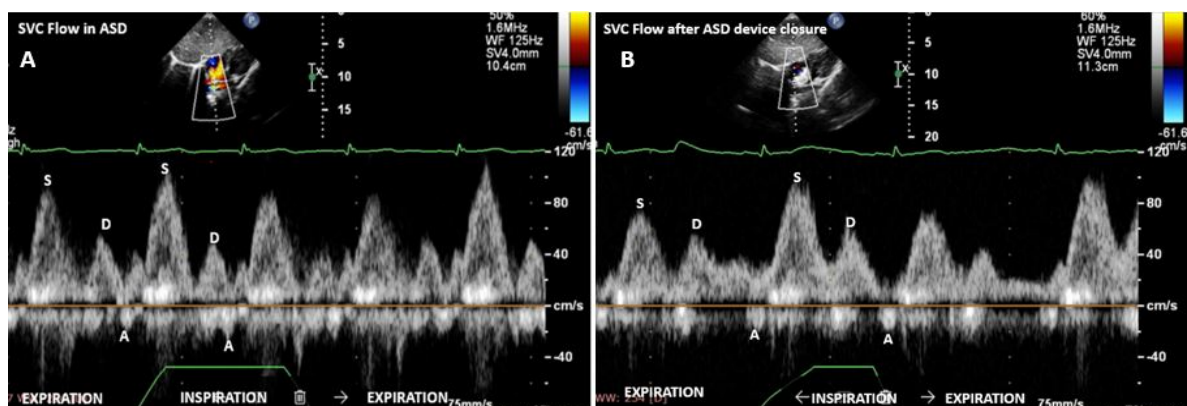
Superior venacava flow doppler before and after device closure (from subcostal window). S; systolic forward flow (S-wave), D; diastolic forward flow (D-wave), and A; diastolic atrial reversal of flow (A-wave).
